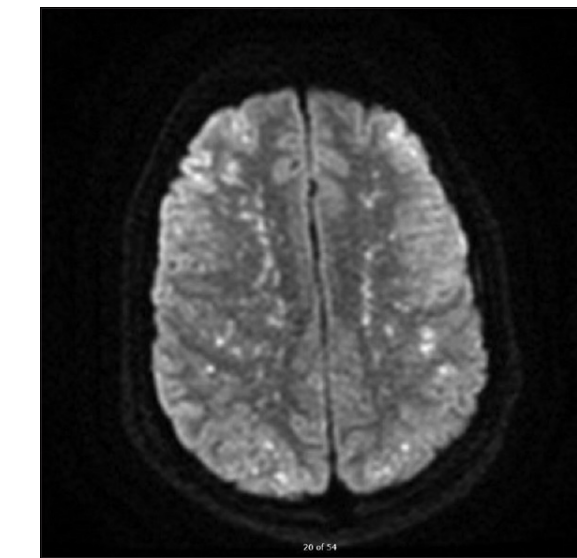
An example of the starfield pattern seen on MRI in cerebral FES¹¹
